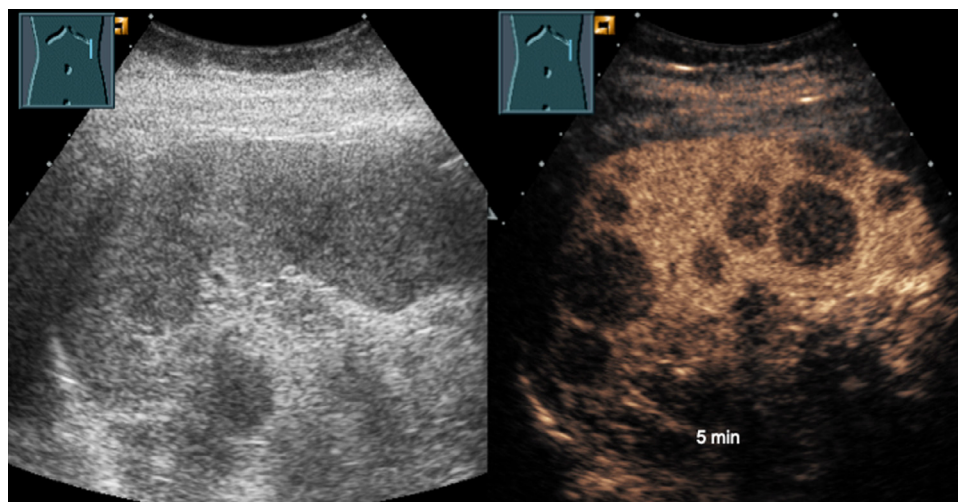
A patient with granulomatous spleen infiltration in sarcoid disease. Inhomogeneous splenic parenchyma in the B-mode ultrasound (left). In the parenchymal phase of CEUS (5 min) the lesions present a hypoechoic enhancement.
